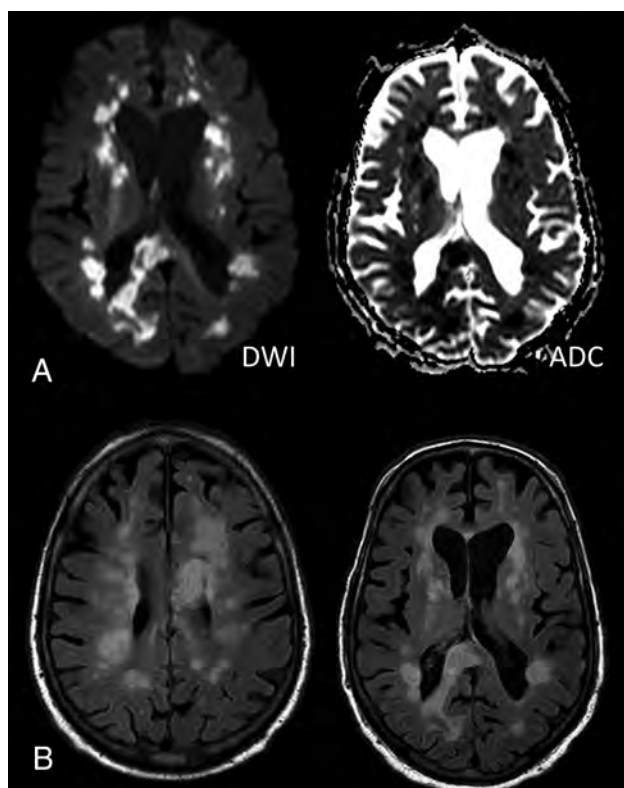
Patient with MERS-CoV infection (on day 28). A, DWI and ADC mapping show diffusion restriction of the multiple white matter lesions. B, Axial FLAIR images show multiple hyperintense lesions in the subcortical areas and deep white matter of the frontal, temporal, and parietal lobes bilaterally as well as in the corpus callosum. Images reprinted from Arabi et al.⁴⁷
